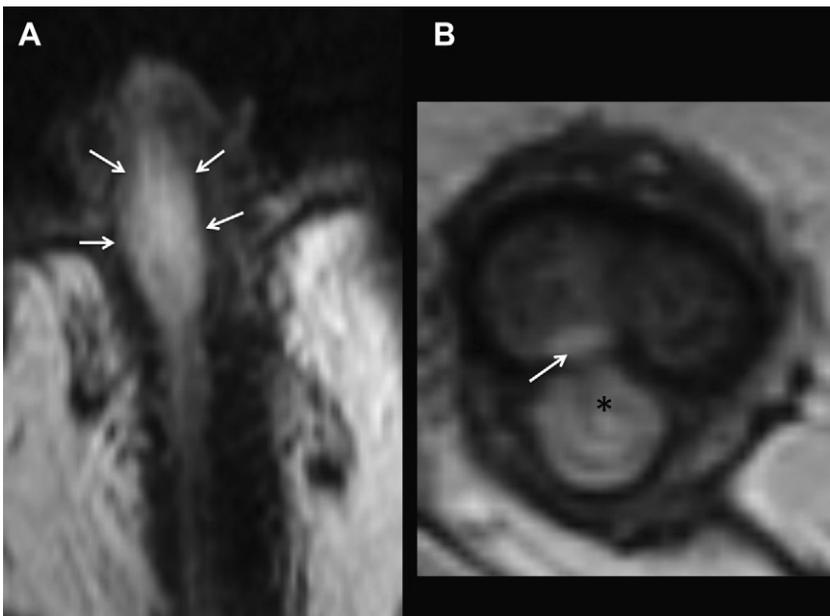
MR imaging of penile fracture with injury of the urethra. (A) Long-axis T2-weighted image demonstrates expansion and increased T2 signal within the corpus spongiosum (arrows) concerning for urine extravasation and edema. (B) Axial image demonstrates fluid signal within the substance of the corpus spongiosum (black asterisk) extending into the right corpus cavernosum (white arrow). The tunica albuginea at this level is ill defined. A penile fracture with urethral injury was suspected. Surgical exploration and cystoscopic urethral visualization confirmed this diagnosis.
